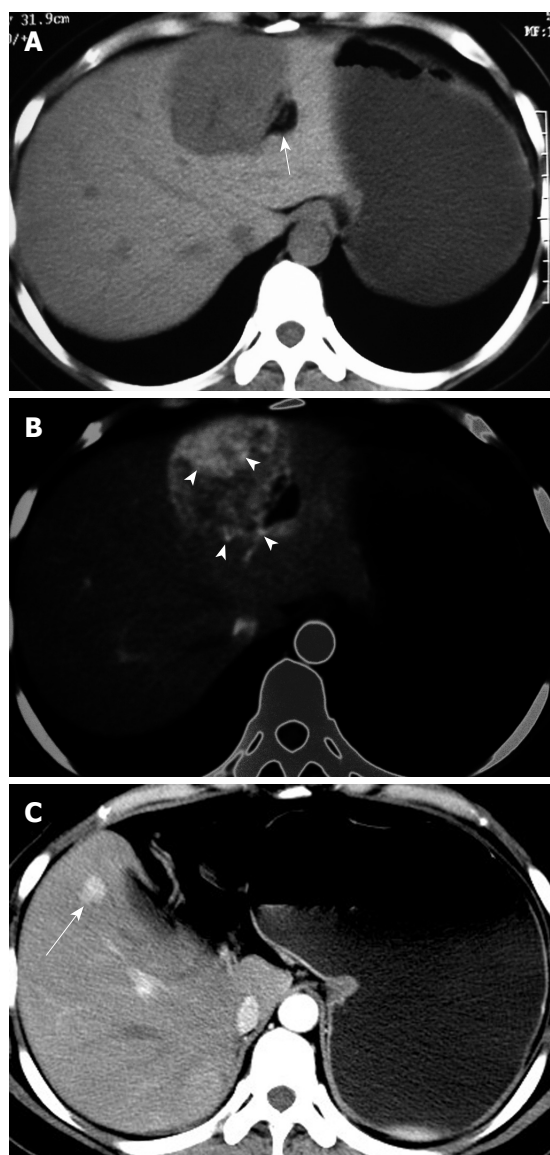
33-year-old woman with epithelioid angiomyolipoma in left lobe of liver (patient 7). A: Non-enhanced CT scan shows hypoattenuating lesion with fat components (arrow, CT value mean-35 Hu) in segments II/III/IV; B: Contrast-enhanced CT scan shows inhomogeneous enhancement lesion with punctiform or filiform enhanced vessels (arrowheads, the window width and level was adjusted) on arterial phase; C: Contrast-enhanced CT scan at 1-year follow-up shows enhanced recurrent nodule (arrow) on arterial phase image after the left lobe surgery.
